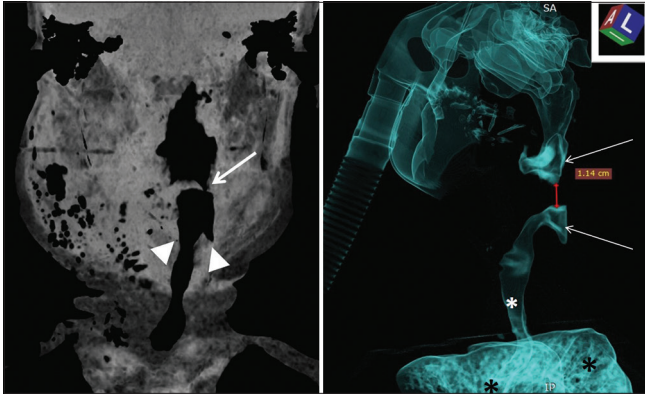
Computed tomography coronal minimum intensity projection image of the neck (left image) and left lateral oblique volume-rendered image reconstructed with airway algorithm (right image). These images show the compromised airway, which measures 1.14 cm in length (depicted between the red calipers in the right image) and includes just a tiny patent part left (arrow in the left image). Furthermore, in the left image, the piriform sinus is obliterated on the right side compared to the left normal side (arrowheads). In the right image, the patent airway above and below the narrowed part are shown with white arrows, the patent trachea with a white asterisk and the lungs with black asterisks.
